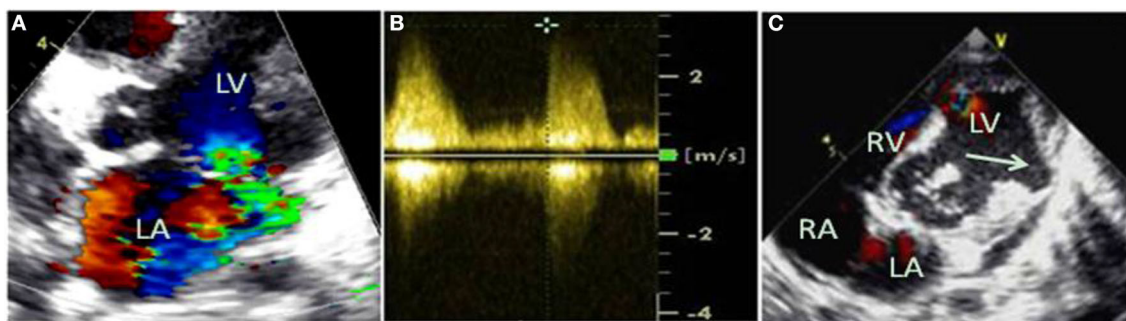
Color Doppler flow imaging revealed severe mitral regurgitation (A), and mild pulmonary hypertension was estimated by continuous-wave doppler (B). Opposite the muscular ventricular defect, a ventricular aneurysm on the left ventricular posterior wall was formed (C), indicated by the arrow.
